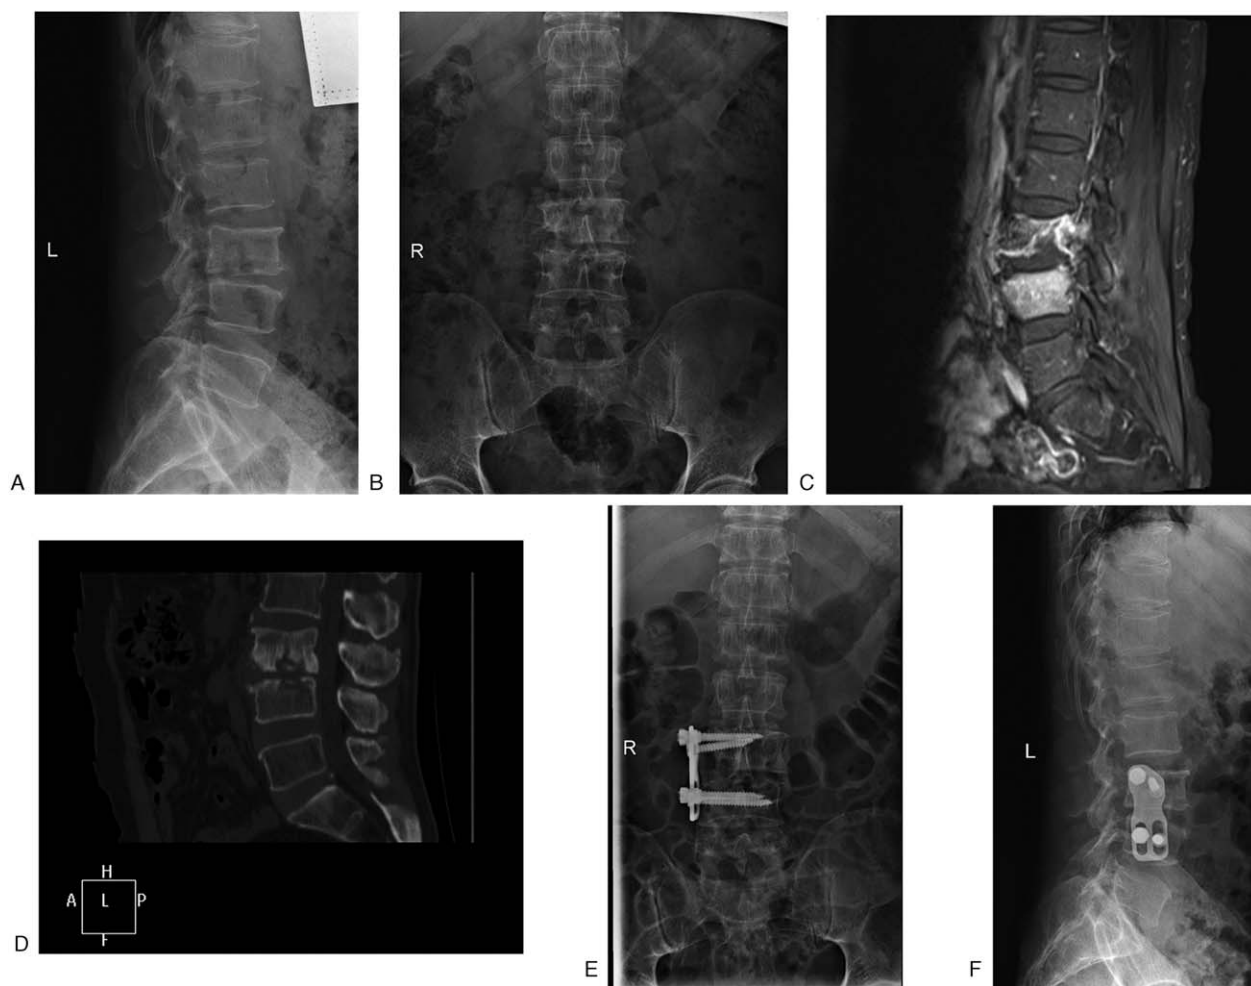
Representative case of a 63-year-old male patient. (A–B) Preoperative X-ray suggested that L3 and L4 had vertebral bone destruction, damaged intervertebral space, and narrowed intervertebral space. (C) Preoperative MR suggested that L3 and L4 had bone marrow edema. (D) Preoperative CT suggested that L3 and L4 had vertebral bone destruction and narrowed intervertebral space. (E–F). Postoperative X-ray suggested adequate position of internal fixation.
